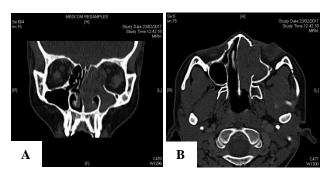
(A and B): An axial and coronal CT scan view showing glomangiopericytoma filling the left nasal cavity extending into the left maxillary sinus and left extraconal space abutting on the medial rectus muscle.
